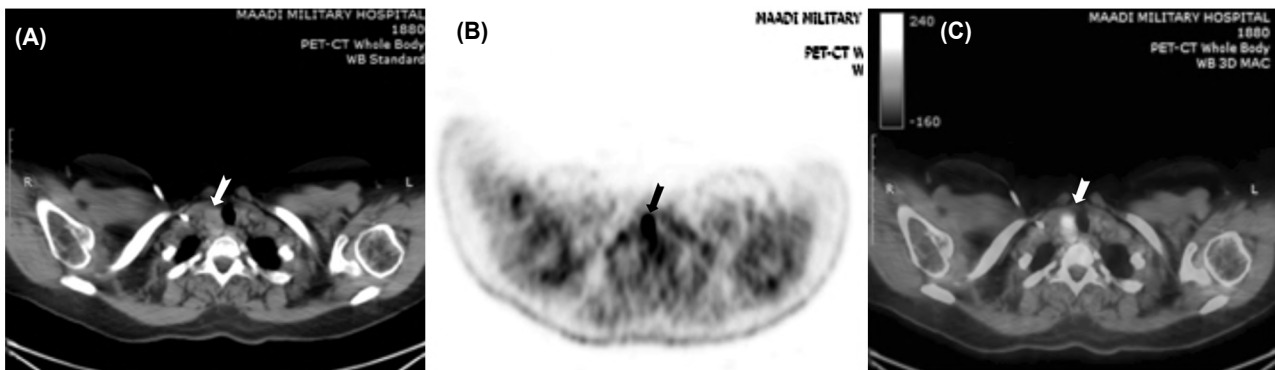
Axial multislice (128) non-enhanced CT. (A) Axial PET (B) and axial PET/CT (C) Images show a metabolically active nodule in the mildly enlarged right thyroid lobe with SUVmax 6.5 (notched arrows). US study images showed a hypoechoic solid nodule measuring 15x20mm with ill-defined outlines, corresponding to the focal uptake on PET-CT scan. US-guided FNAB was a follicular neoplasm lesion.
